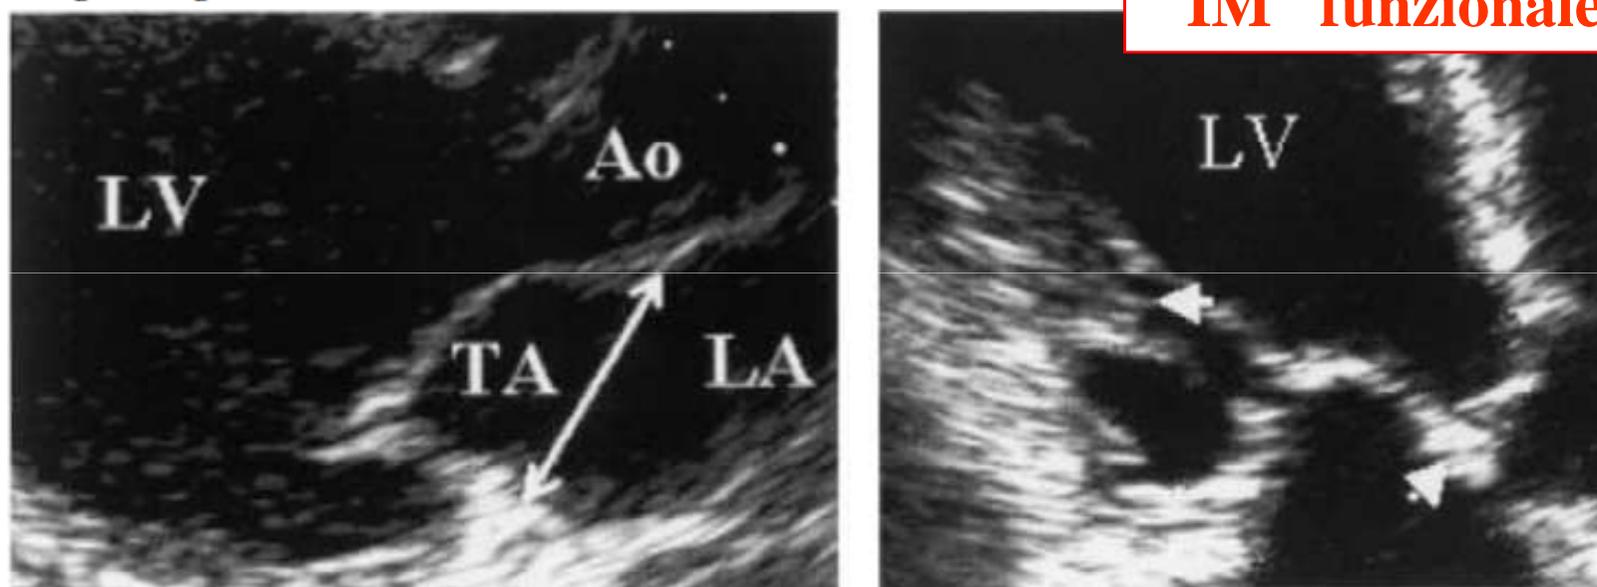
(Left) Parasternal long-axis view of aorta (Ao), left ventricle (LV), and left atrium (LA) showing tenting area (TA). (Right) Apical long-axis view demonstrating measurement of the distance between the posterior papillary muscle and the intervalvular fibrosa (arrowheads).
